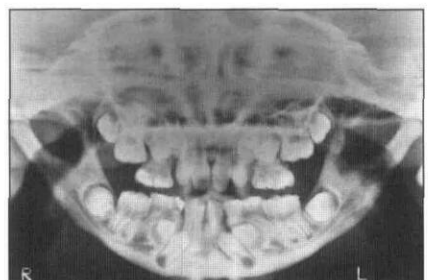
Radiograph shows small mandible, lack of ramus, severe crowding, absence of second premolars, and the lower second molars developing in an abnormal orientation.
